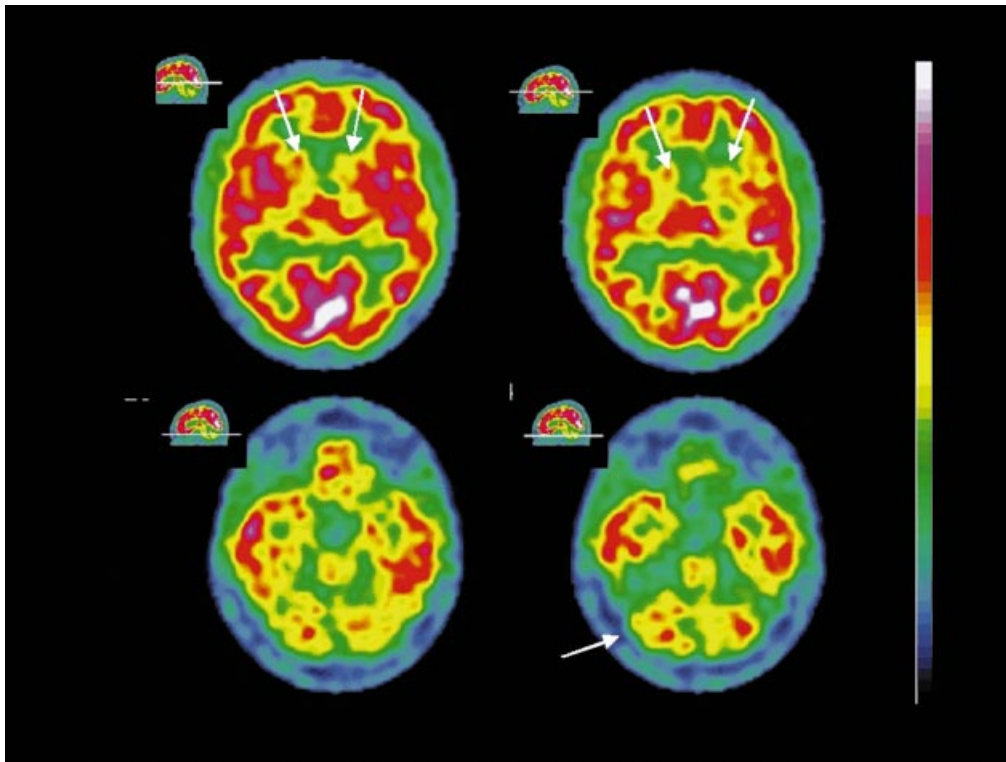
Brain ECD-SPECT in patient F3P2. Arrows indicate cerebellar hypoperfusion in patient F3P2 (*below*) associated with moderate bilateral hypoperfusion in the caudate nuclei (*above*).
